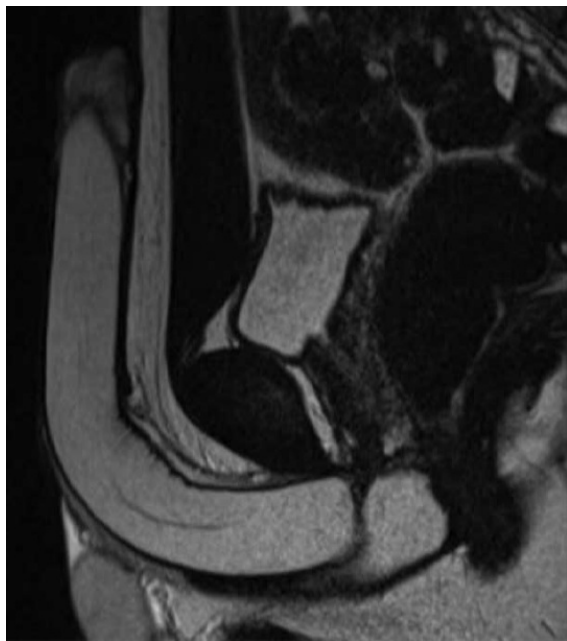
Normal penile MRI (under vasoactive drugs).
